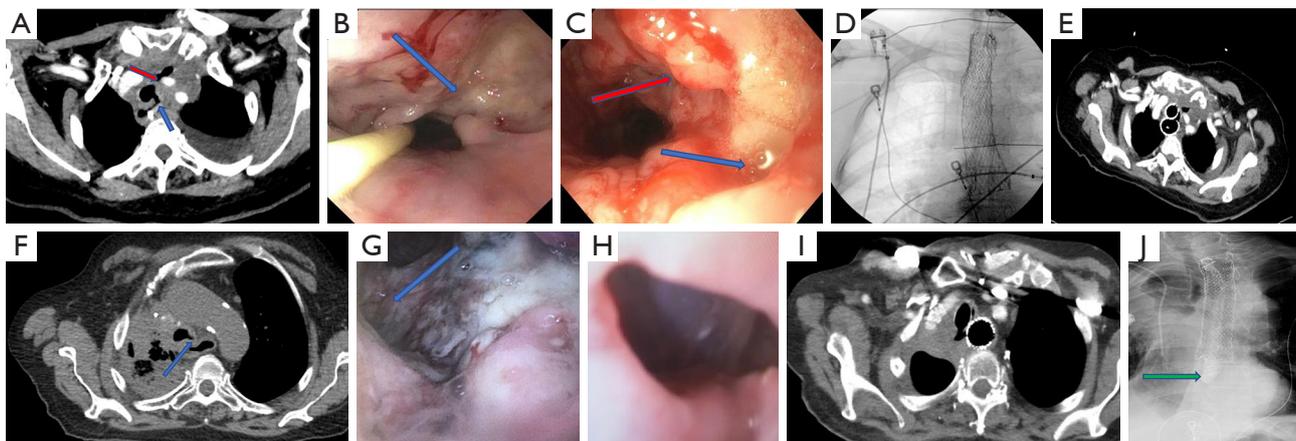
Two case reports of dual stenting for TEF with a quality control evaluation. Case 1 top row—(A) CT of the chest with a malignant trachea-esophageal (blue arrow) and tracheo-mediastinal (red arrow) fistulas. (B) Endoscopic image with nasogastric tube in place and visible TEF (blue arrow). (C) Bronchoscopic image with visible TEF (blue arrow) and tracheo-mediastinal fistula (red arrow). (D) Fluoroscopy image post stents placement. (E) Quality control CT chest with visible fully covered metallic stent size 16 mm × 60 mm in the proximal trachea and fully covered 16 mm × 120 mm metallic stent in the proximal esophagus. Case 2 lower row—(F) CT chest with a malignant trachea-esophageal fistula located 1.5 cm from the carina (blue arrow) and narrowing of the distal trachea. (G) Bronchoscopic image and visible TEF (blue arrow). (H) Endoscopic image with visible silicone Y stent providing incomplete seal of the fistulous tract. (I) Quality control CT chest with silicone Y stent size 16–13–13 mm in the trachea and fully covered stent size 23 mm × 120 mm in the esophagus. (J) Quality control esophagram showing a contrast passing distally through the esophageal stent (green arrow). CT, computed tomography; TEF, tracheoesophageal fistula.
